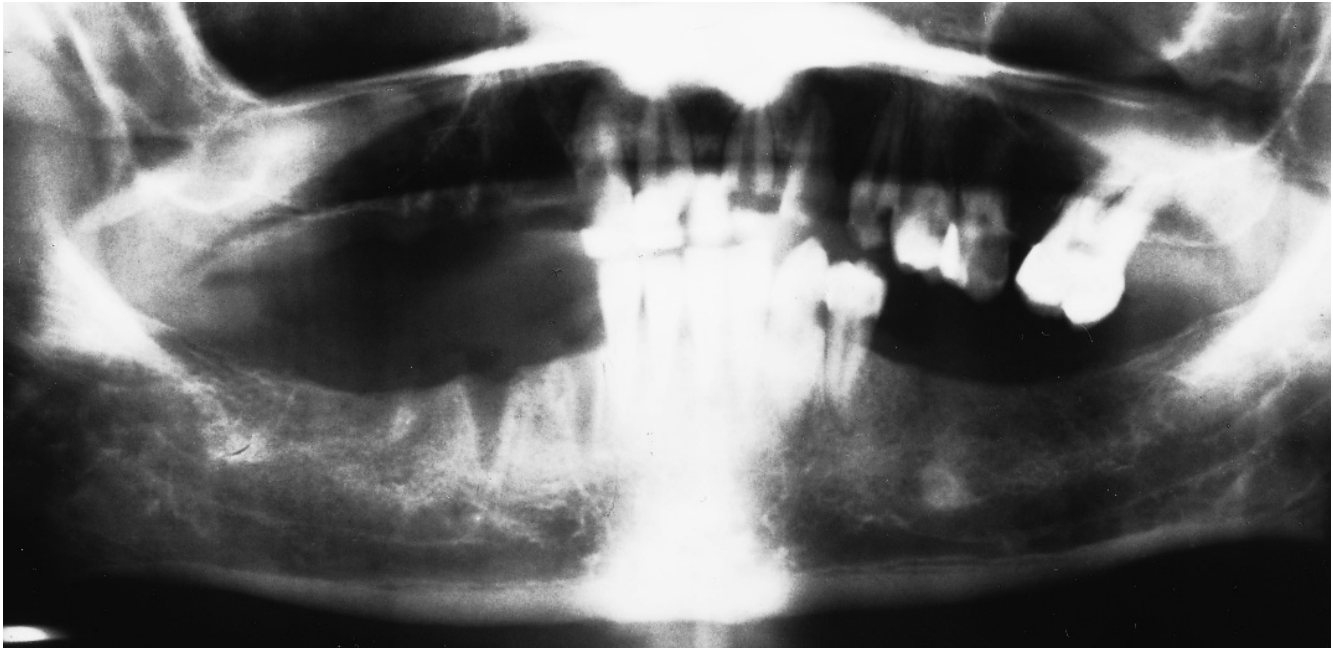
Radiographic comparison. A comparison of the radiograph of the mandible found in the incinerator (Figure 23.3) with the radiograph taken of Harry Jones before his death (shown here) revealed a correspondence in the lack of teeth, or radiolucent sockets, in the approximately 5-mm diameter “calcified density” in the body of the mandible, in trabecular bone patterns along the mandibular canal and inferior border of the mandible, and in the outline of the mandible. Aside from the loss of teeth, there are no radiographic inconsistencies between the 1981 films of Harry Jones and the 1984 films of the unknown mandible fragment from the incinerator bin. This provided a positive identification of the deceased.
